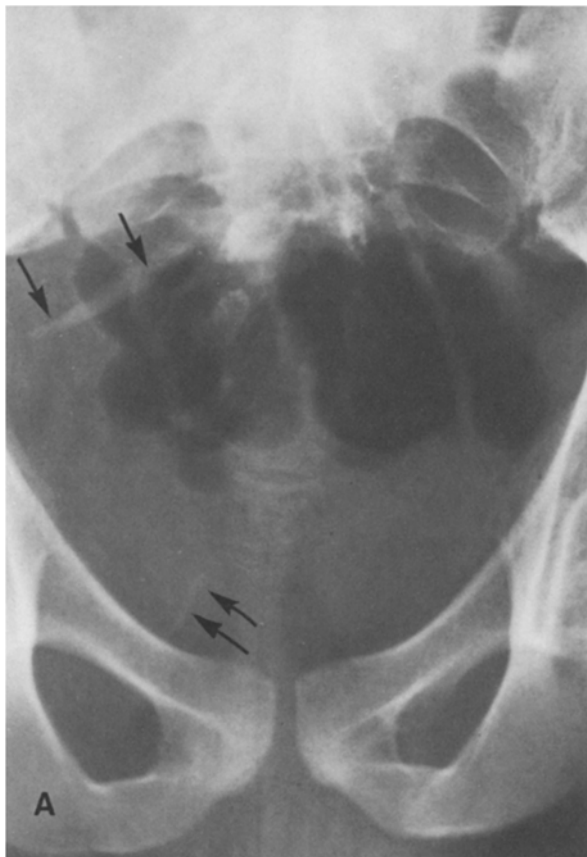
A An anteroposterior roentgenogram of the pelvis shows two linear bony structures overlying the soft tissues of the pelvis on the right side (*arrows*). The larger arrows point to the longer of the two bony densities. The smaller of the two (*smaller arrows*) linear bony densities is also located on the right side but low in the pelvic cavity just above and lateral to the right pubic bone. A third linear density is apparent in the pelvic soft tissue on the left side just opposite to the bony opacity noted in the foregoing. B and C Lateral and oblique views confirm the presence of two of the three bony densities (*arrows*)
